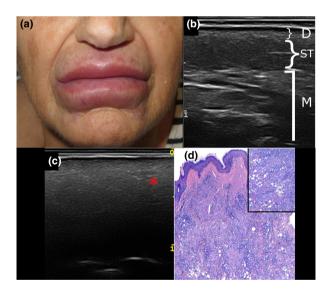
(a) Oedema and induration of lips due to foreign body granulomas formation after BRAF inhibition treatment. (b) High-frequency ultrasound image of normal skin layers and deeper structures. D, dermis; M, muscle; ST subcutaneous tissue. (c) High-frequency ultrasound image of silicone oil injection (longitudinal view). Hyperechoic deposits (*) with a 'snowstorm' pattern affecting the supra-labial skin. (d) Granulomatous reaction affecting the whole dermis and hypodermis ($100 \times magnification$). Prominent vacuolated histiocytes and giant multinucleated foreign body type cells ($200 \times magnification$).
